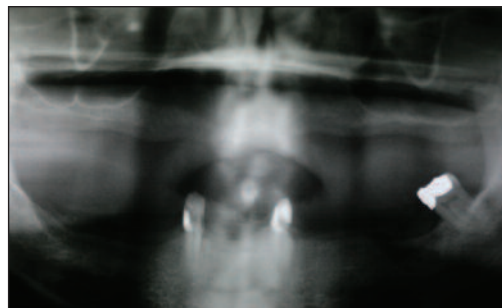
Preoperative panoramic radiograph (Panorex) of severely atrophic maxilla and mandible with only 3 remaining teeth.
